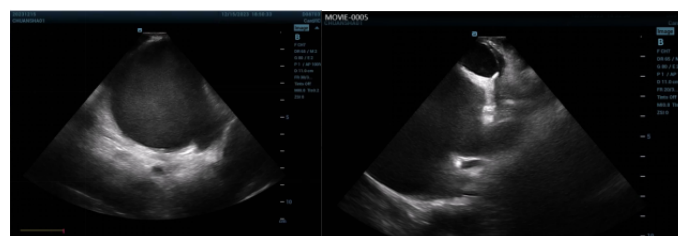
A) Intracardiac Echocardiography (ICE) exploration of the right atrial septum, verifying the absence of a thrombus in the left atrial appendage orifice. B) ICE exploration of the right ventricular outflow tract, verifying the absence of a thrombus within the left atrial appendage body.
